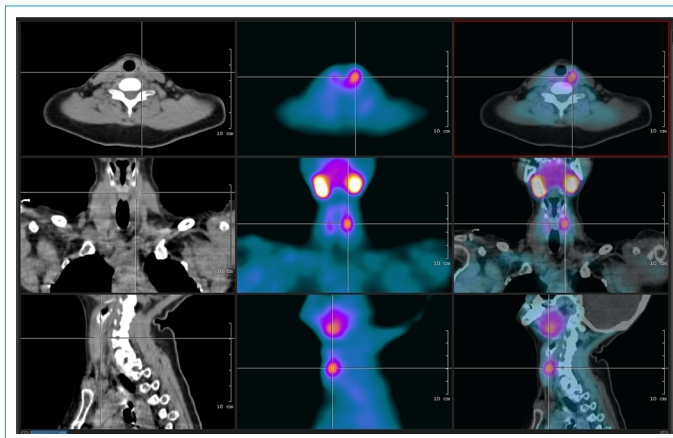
Sestamibi scintigraphy + single-photon emission computed tomography found the accurate localization of 15 mm diameter subcapsular adenoma on the left upper quadrant.
